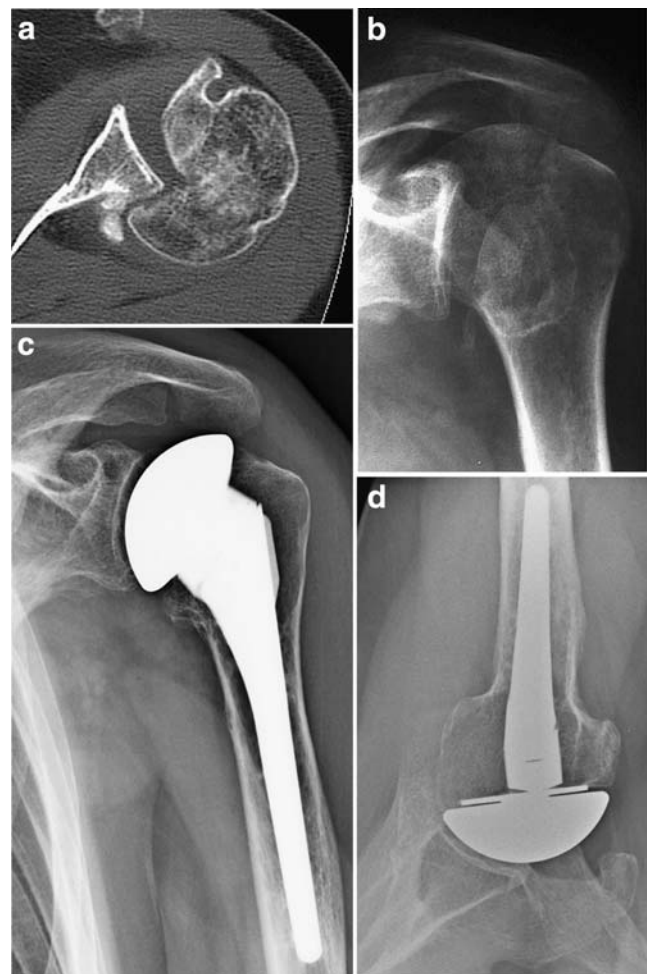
a Axial CT scan of a left shoulder with locked posterior fracture dislocation with a destruction of the humeral head of more than 50%. b True anteroposterior X-ray (same patient as a). c Postoperative X-ray nine years after hemiarthroplasty at follow-up. There is a centred gleno-humeral joint without massive glenoid erosion. Stress shielding at the humeral metaphysis is noted. d Postoperative X-ray, axillary view. The joint is centred with no marked erosion of the glenoid or radiolucent line at the humeral stem
